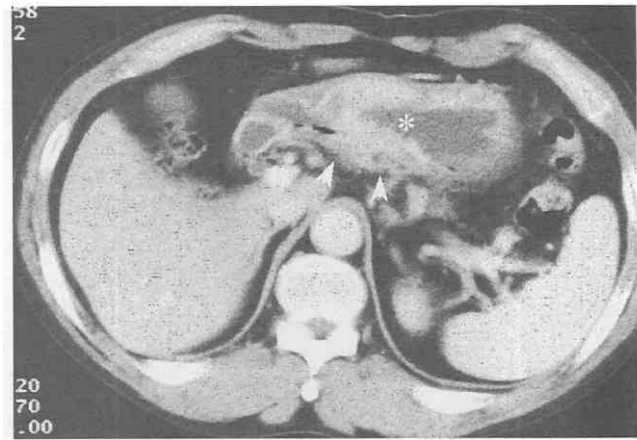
Gastric cancer with serosal invasion. CT scan shows circumferential gastric wall thickening (asterisk) with perigastric tumor infiltration (arrowheads).
